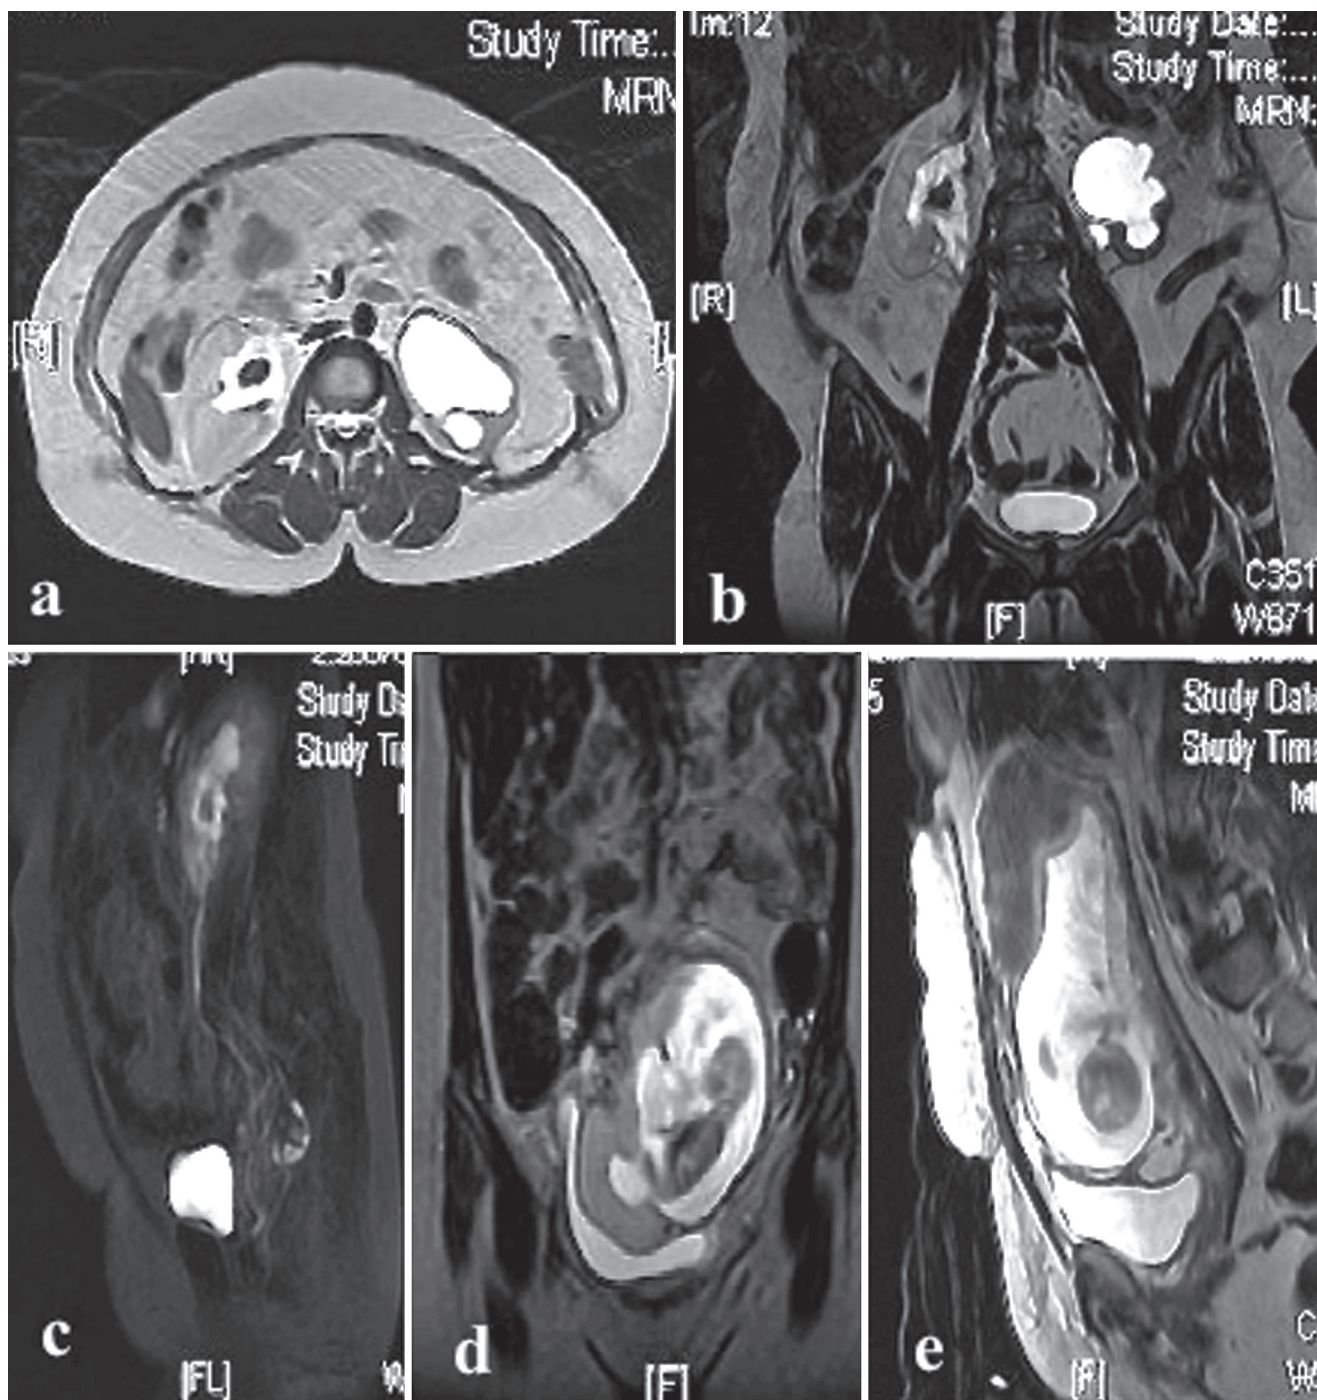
MRI-MRU. (a) Coronal section T2 image showing signal void stone in the right kidney and picture of left pelviureteric junction obstruction (PUJO). (b) Axial section T2 image showing signal void stone in the right kidney with marked left hydronephrosis. (c) Sagittal
